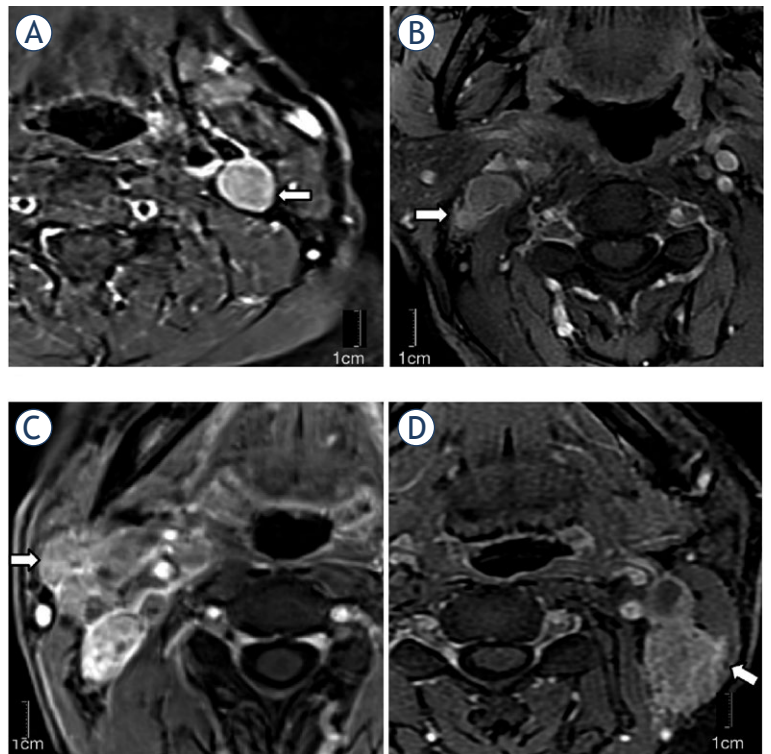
Axial T1-weighted fat-suppressed contrast MRI images of grade 0–2 extranodal extension (ENE) in four stage II nasopharyngeal carcinoma patients. (A) Grade 0: without ENE; (B) Grade 1: lymph node (LN) infiltrating surrounding fat; (C) Grade 2: matted LNs; and (D) Grade 3: LN infiltrating sternocleidomastoid muscle (white arrows).
